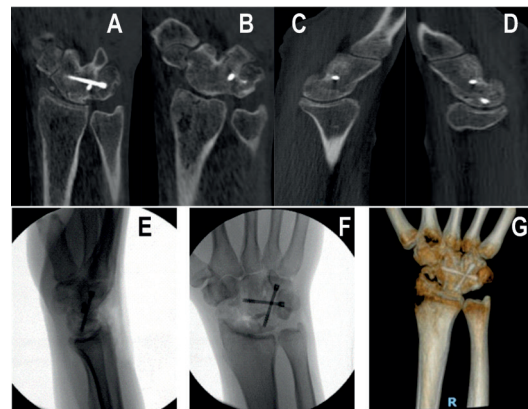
A-D) CT scan at 2 years and 3 months after surgery showing the placement of the screws and the rooting of arthrodesis; E, F) Radiographic evaluation at 1 year after surgery confirming screws position; G) CT 3D scan at 2 years and 3 months after surgery which confirms the positioning of the screws (Ghargozloo D, 2020)
